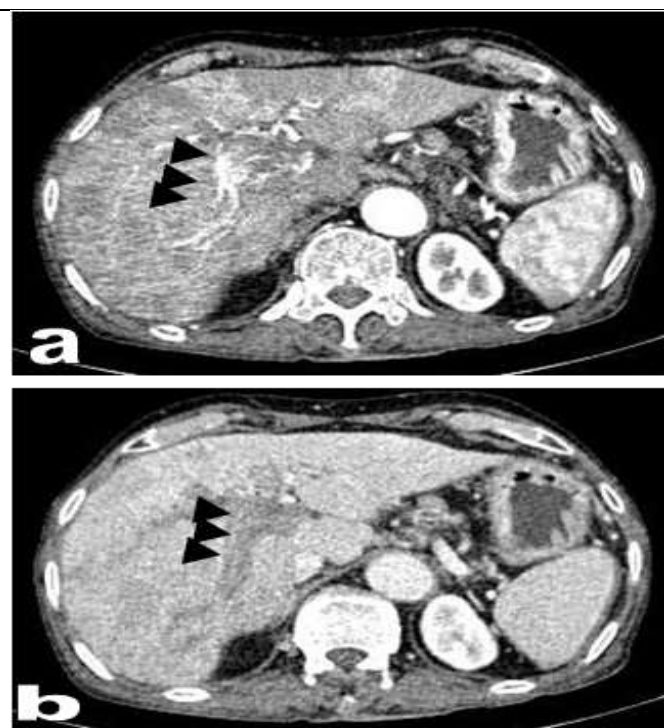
Male patient 76 years old, presented by jaundice and abdominal pain and had a history of HCC, Triphasic CT showed Heterogeneously enhancing hepatic parenchyma with right portal vein thrombus showing enhancement at the arterial phase [75 HU], complicated by right arterio-portal fistula (fig. 3A) and washout in portovenous phase [80 HU] (fig. 3B).
